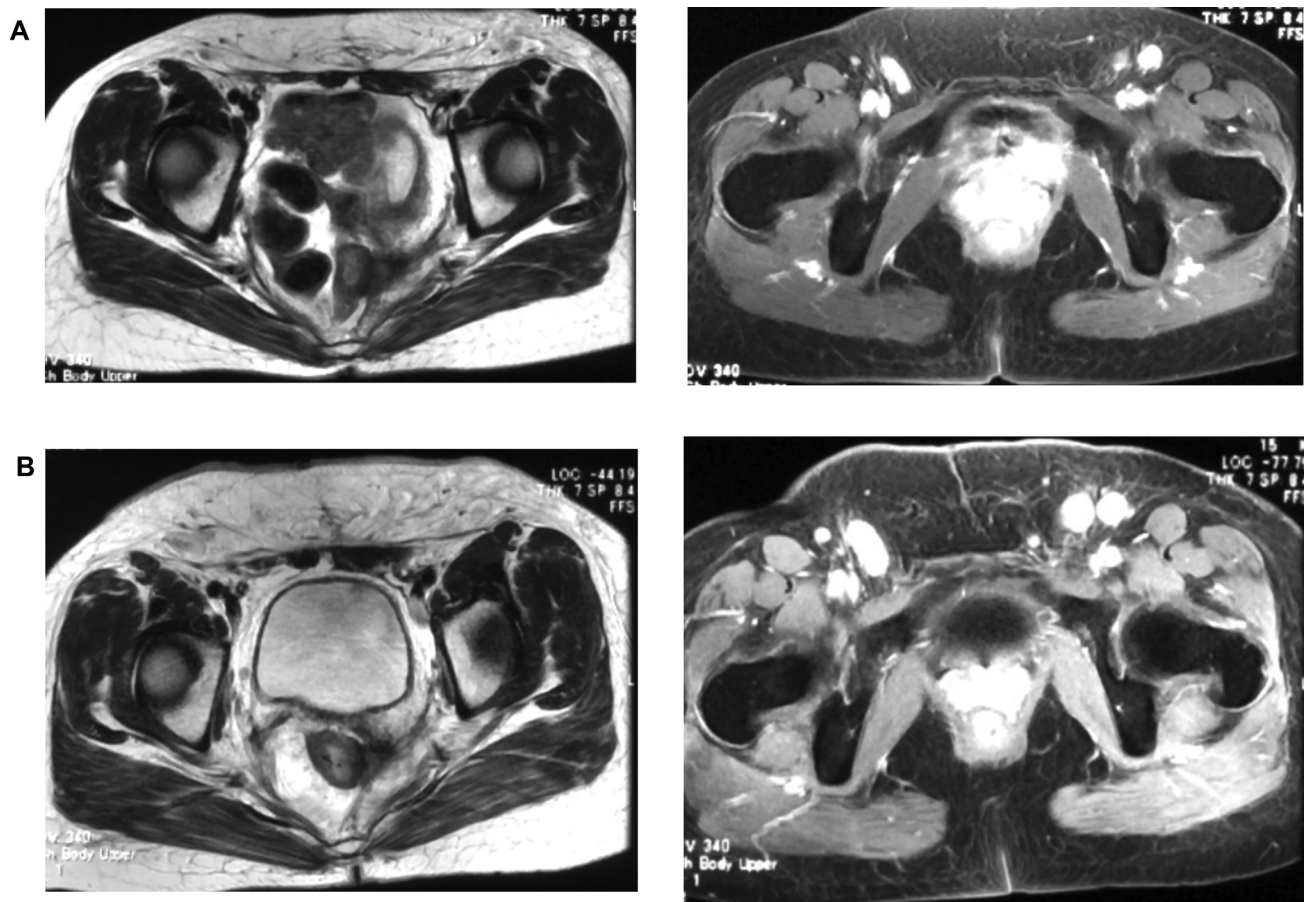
Magnetic resonance images of the pelvis of case 1. A: 40-mm Recurrent tumor in left parametrium and metastatic tumor in the inguinal lymph node were found in January 2008. B: The tumor in the parametrium decreased in size; however, that in the inguinal lymph node was found in May 2008 to have progressively increased in size.
